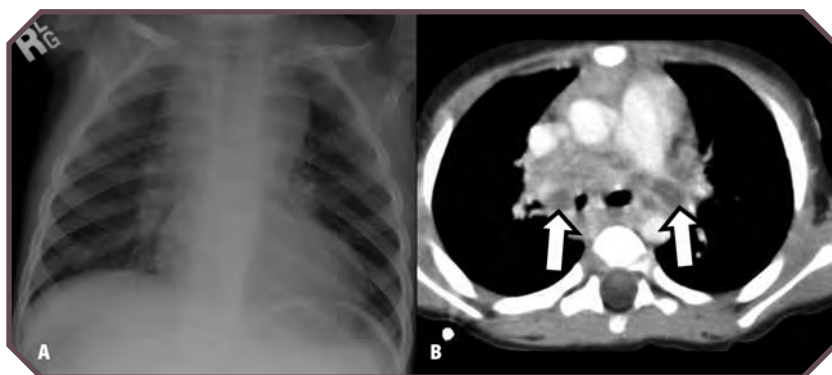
Histoplasmosis in a 6-year-old girl. A. Frontal chest radiograph demonstrates mediastinal widening consistent with marked lymphadenopathy. Fine granular opacity is seen bilaterally, which is suggestive of active inflammation. B. Axial contrast-enhanced chest computed tomographic image demonstrates mediastinal nodes, many with central low attenuation surrounding thick, enhancing walls (arrows).
